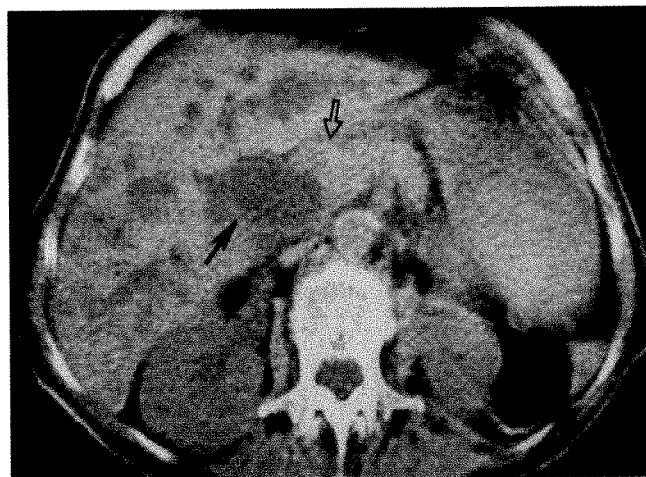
CT scan of 53-year-old woman with jaundice showing marked dilatation of common bile duct (closed arrow) and multiple dilated intrahepatic bile ducts (low density areas). No definite mass within pancreatic head (open arrow) identified. Surgery disclosed adenocarcinoma of pancreatic head as cause of obstructive jaundice.
